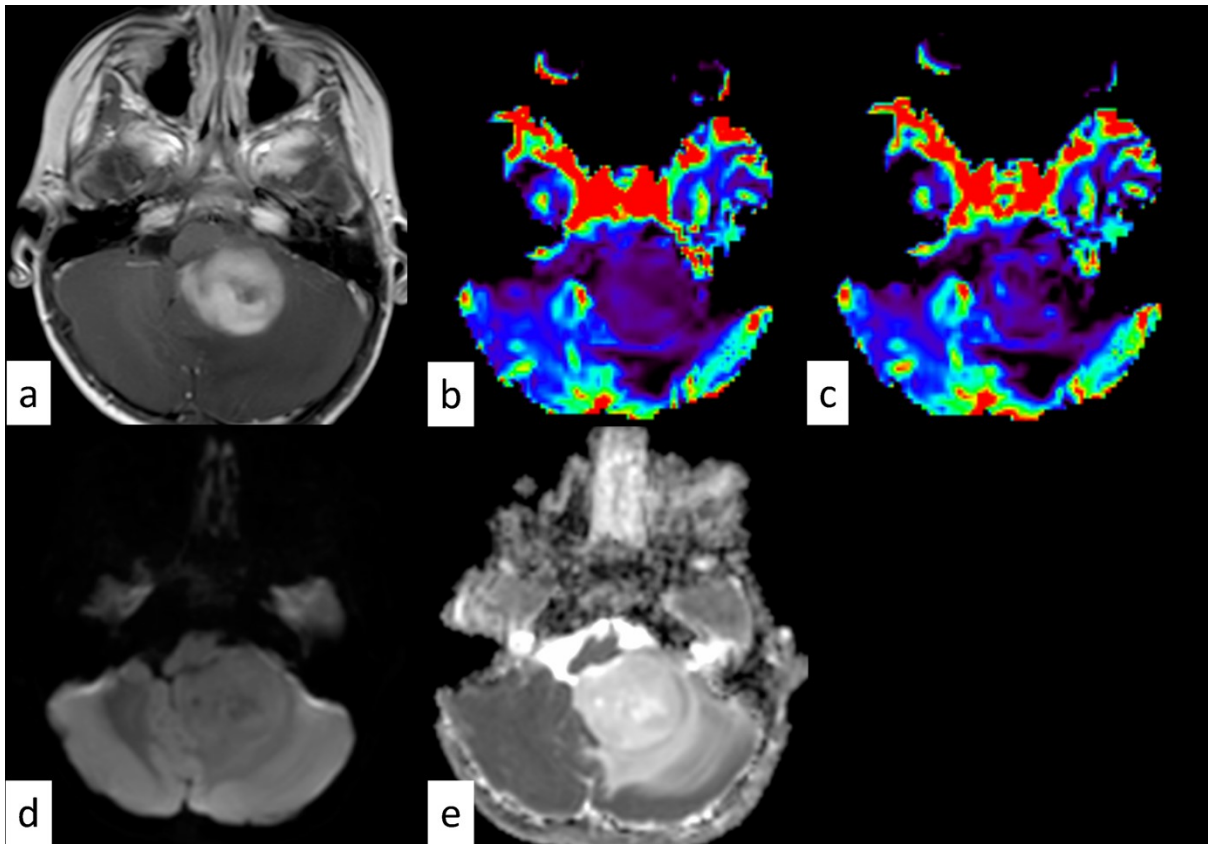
Pilocytic astrocytoma in a 2-year-old girl. Magnetic resonance imaging showed a mass with cystic change in the cerebellum, causing hydrocephalus (not shown). The tumor shows heterogeneous enhancement on post-contrast T1-weighted imaging (a) without an elevated normalized relative cerebral blood volume (b, 0.53) or normalized relative cerebral blood flow (c, 0.76). The tumor shows intermediate intensity on diffusion-weighted imaging (d) with a high mean normalized apparent diffusion coefficient (2.04) and minimum normalized apparent diffusion coefficient (1.45) (e). The tumor was resected but recurred 5 months later.
